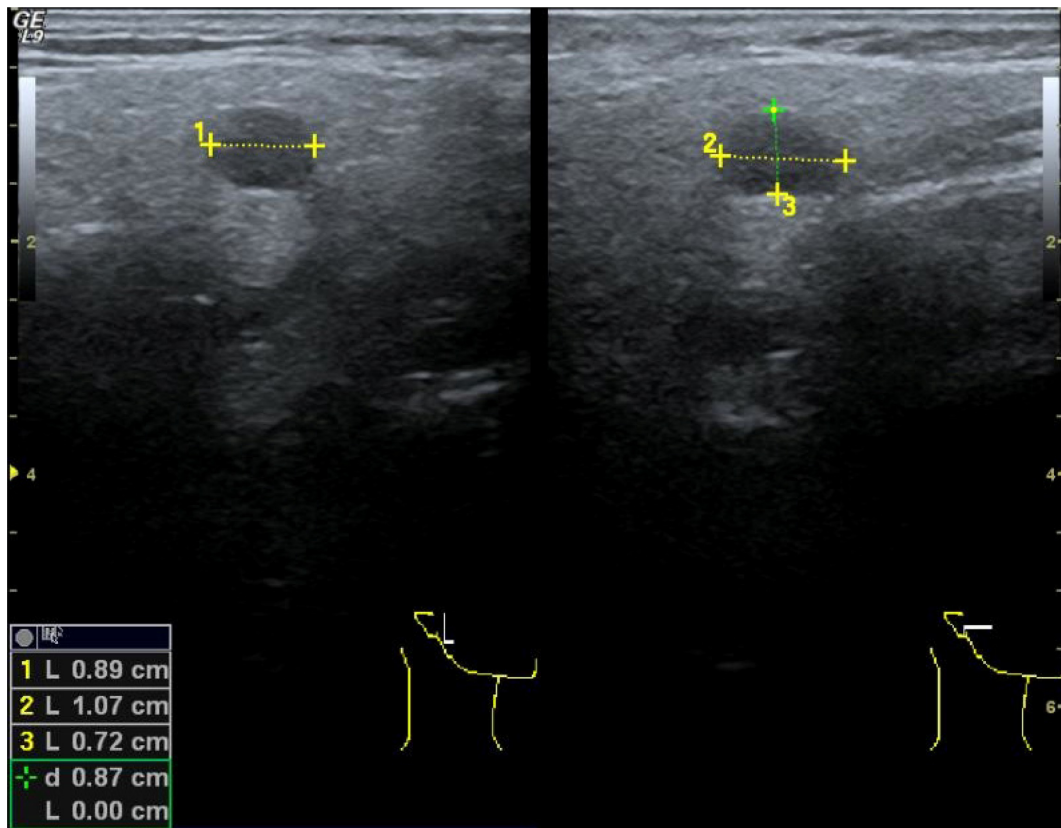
Ultrasonography imaging of the right parotid gland tumour.
